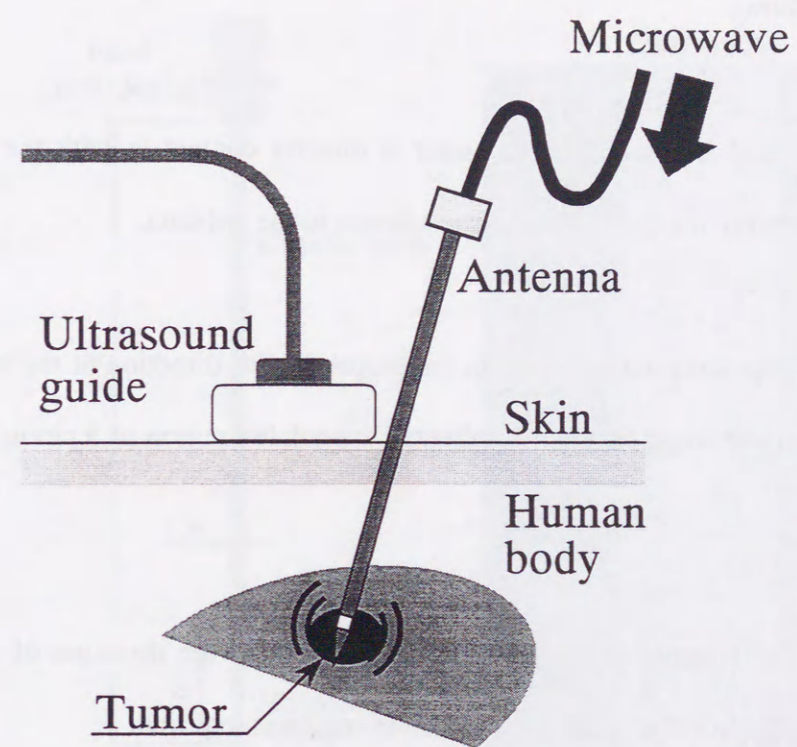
Scheme of the MCT under an ultrasonic guide.
